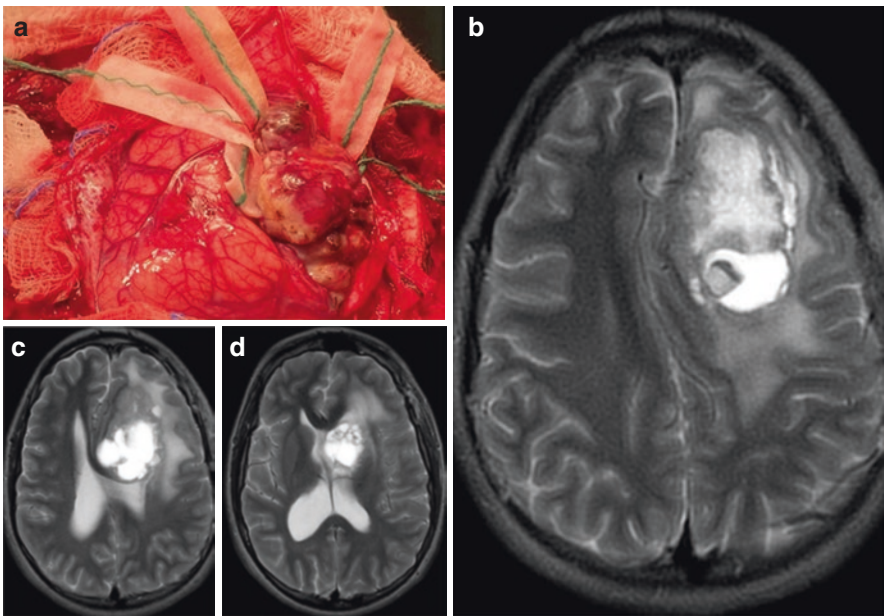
Ependymoma of the left lateral ventricle (*YAP* fusion). Surgical removal (a) and MRI findings (b–d)
